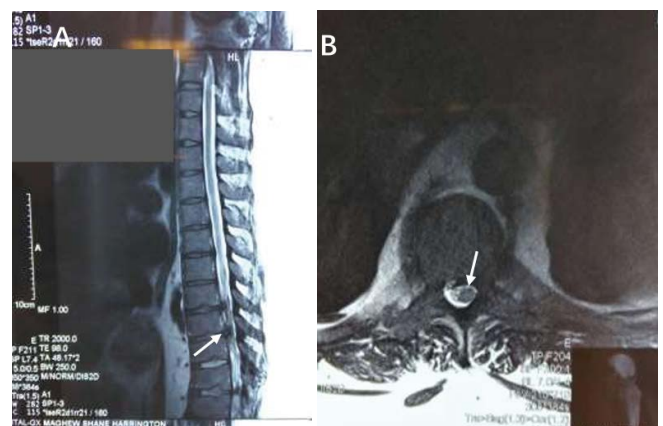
MRI showed T8-9 (A) a huge disc sequestration on the left occupied 50% of the spinal canal (arrow in B), causing severe spinal cord compression.
